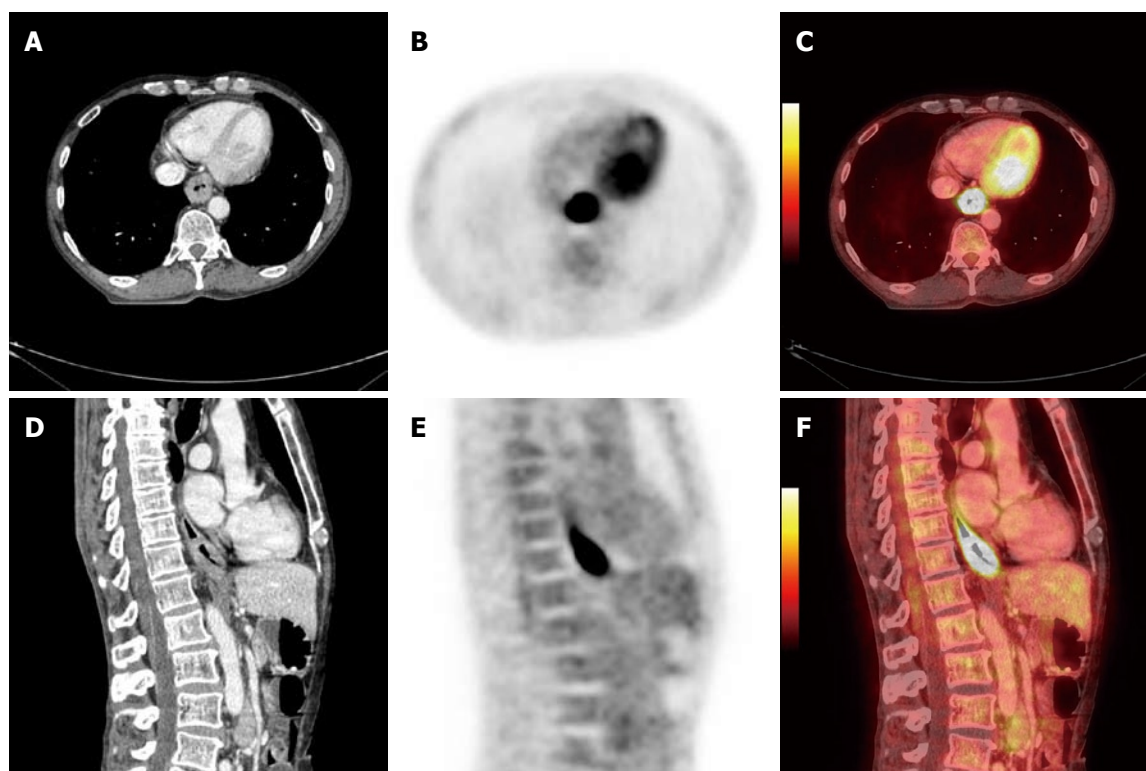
Positron emission tomography/computed tomography images of 61-year-old man with primary squamous cell carcinoma in distal part of the esophagus T3N0M0 prepared in treatment position for radiotherapy planning. A: Computed tomography (CT), axial slice; B: Positron emission tomography (PET), axial slice; C: PET/CT fusion, axial slice; D: CT, sagittal slice; E: PET, sagittal slice; F: PET/CT fusion, sagittal slice.
